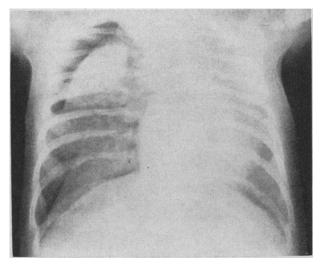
Chest radiograph in Case 13, showing a pneumothorax on the right side with marked consolidation of the right upper lobe. The right lower lobes and the left lung show the characteristic mottled appearance with peripheral emphysema.
